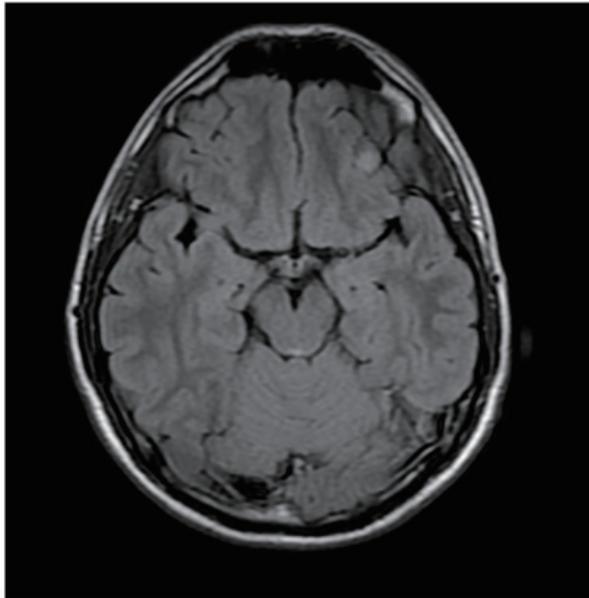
The MRI demonstrates a superficial hyperintense lesion within the left lateral frontal lobe, corresponding to Brodmann's cortical area 47 (T2 Flair).
